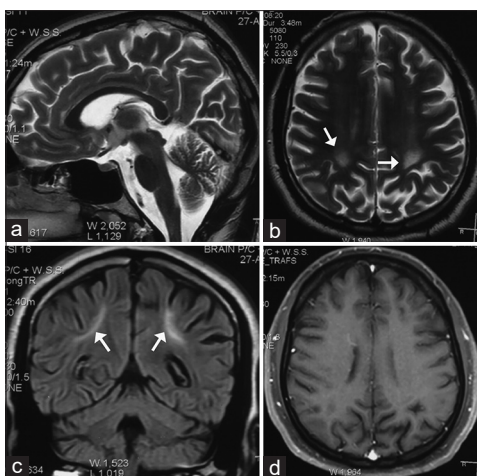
Sagittal T2-WI (a) shows normal thickness and signal intensity of corpus callosum. Axial T2-WI (b) and coronal FLAIR image (c) shows bilateral symmetrical periventricular white matter hyperintensities (arrows). No enhancement is seen in post-gadolinium axial T1-WI (d)
